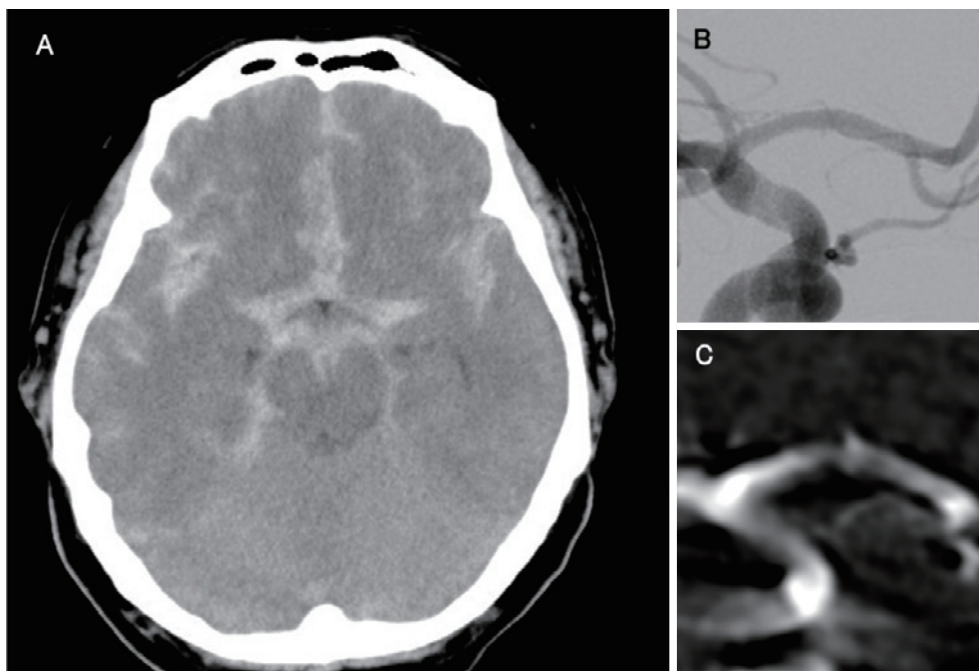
Computed tomography of the head showed diffuse subarachnoid hemorrhage (A). Digital subtraction angiography (B) and three-dimensional rotational angiography (C) showed a wall irregularity in the A1 segment of the right anterior cerebral artery.
